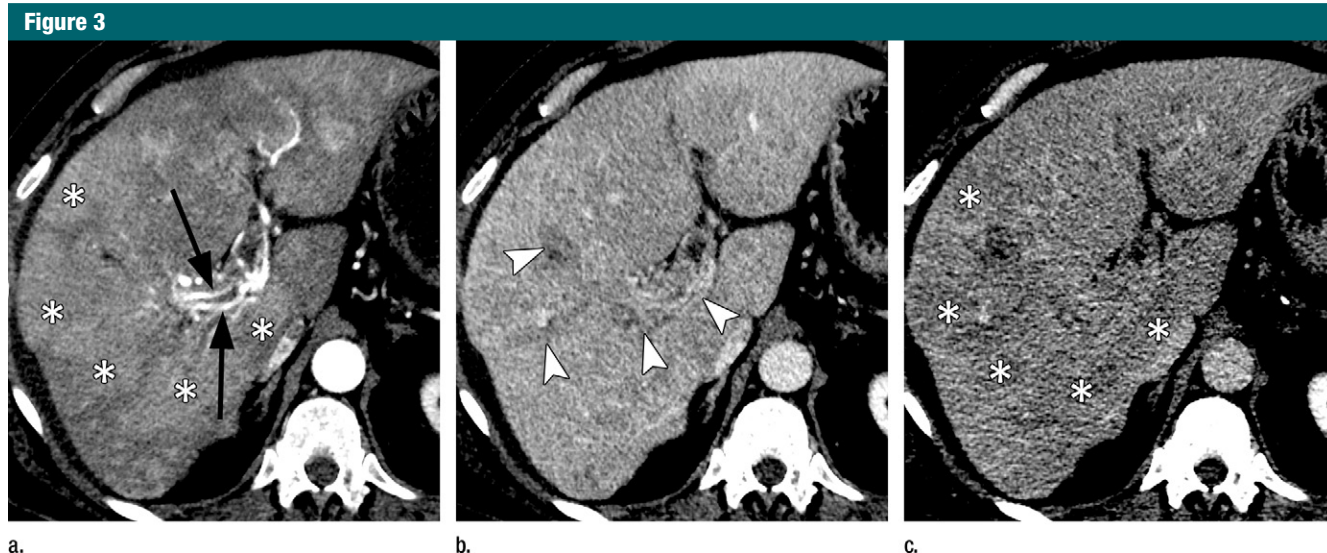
Images in a 64-year-old man with infiltrative HCC and macrovascular invasion. Axial CT images obtained in the (a) late arterial, (b) portal venous, and (c) 3-minute delayed phases after administration of an iodinated contrast agent reveal heterogeneously enhancing soft tissue expanding the lumen of the right portal vein and its branches consistent (arrowheads) with macrovascular invasion by HCC. Note arterial phase hyperenhancing tumoral arteries (arrows), sometimes described as “threads and streaks,” within the intraluminal tissue. Note patchy areas (*) of arterial phase hyperenhancement and delayed phase partial washout appearance in the liver parenchyma, consistent with infiltrative HCC.
